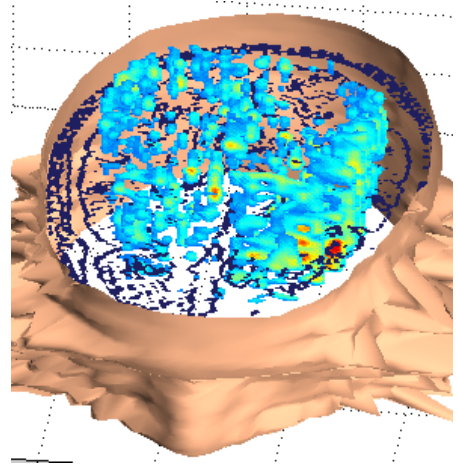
Average 2DII image of brain activity during the first 200 milliseconds. The largest red region corresponds to the initial focal source and most active seizure site. Other concurrent cortical activity is included with the left hemisphere exhibiting greater activity. External distortion of the patient skull is due to artifacts in the MRI data used to generate the 3D surface.
